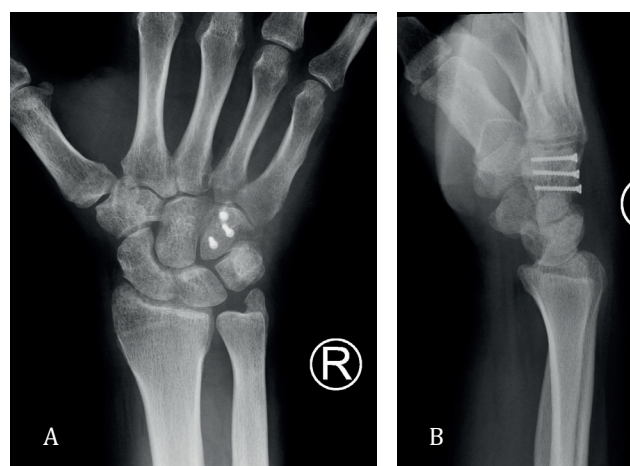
X-ray of the wrist showing a consolidated fracture of the hamate: A – p-a view; B – lateral view
